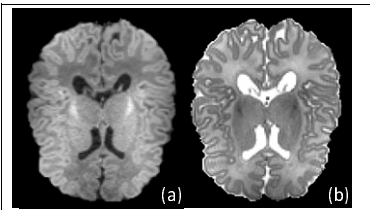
The reconstructed neonatal brain MR images with new imaging protocol. (a) T1 image; (b) T2 image.
